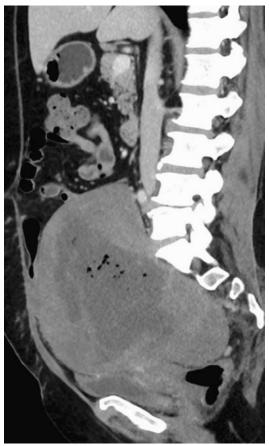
Contrast-enhanced CT sagittal image in venous phase shows a huge lesion located in the lower abdomen and pelvic cavity. Bladder and uterus are compressed. Rectum offsets the central line under lesion's pressure
